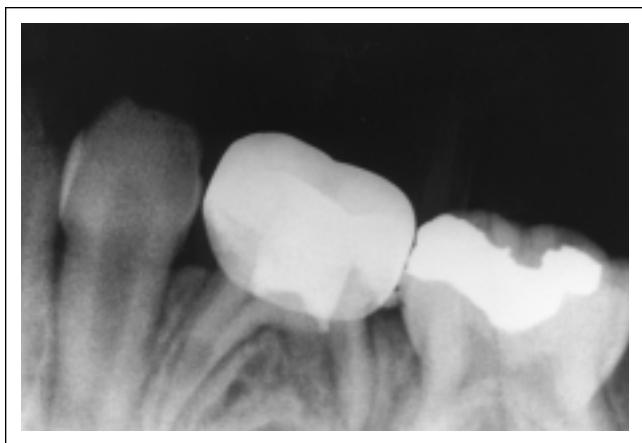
Radiograph showing internal resorption in the mesial root in twenty months follow up time with ferric sulfate. 1a – radiograph of same tooth on the beginning procedure, immediately after pulpotomy.
